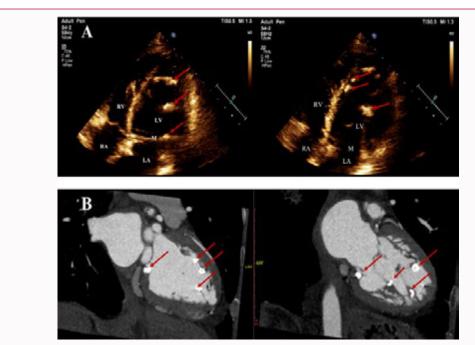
(A) Color Doppler Echocardiography: the apical 4-chamber view showed multiple hyperechoic, oval-shaped masses on the mitral annulus, left ventricle wall, and chordae tendineae (arrows). (B) Computed Tomography of the heart: in the sagittal plane found multiple hyperdense (arrows).
